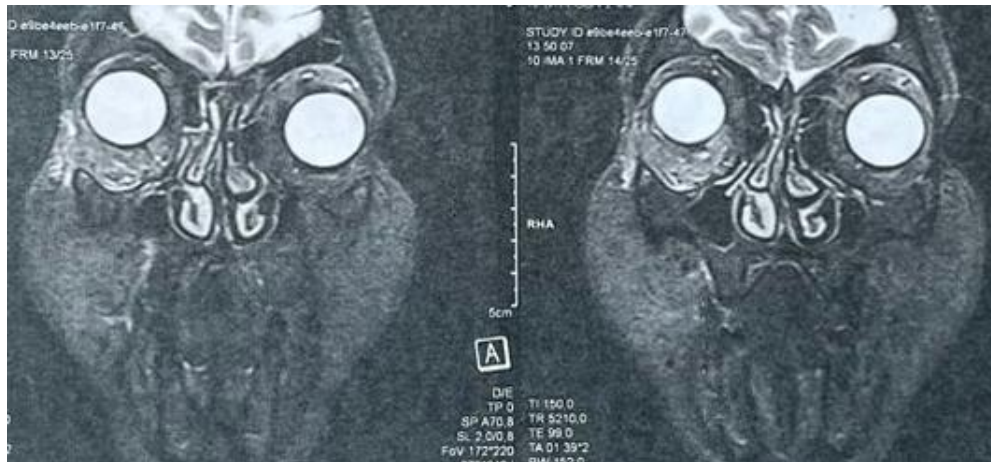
Coronal T2-weighted orbital MRI showing focal thickening of the right inferior rectus tendon with adjacent extraconal fat infiltration
